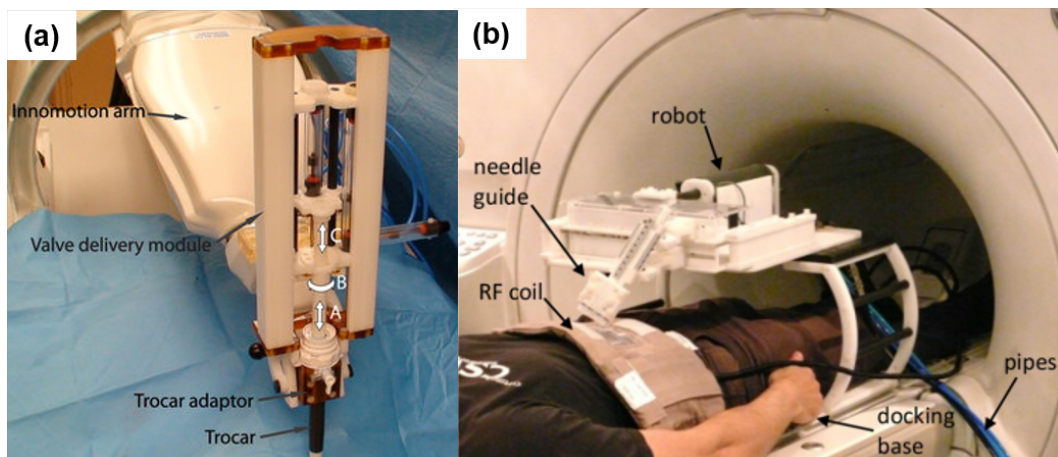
(a) Innomotion robotic system for MRI- and CT-guided needle placement. Image source: [16]. (b) Pneumatic-actuated robot for MRI-guided laser ablation of liver. Image source: [17].
